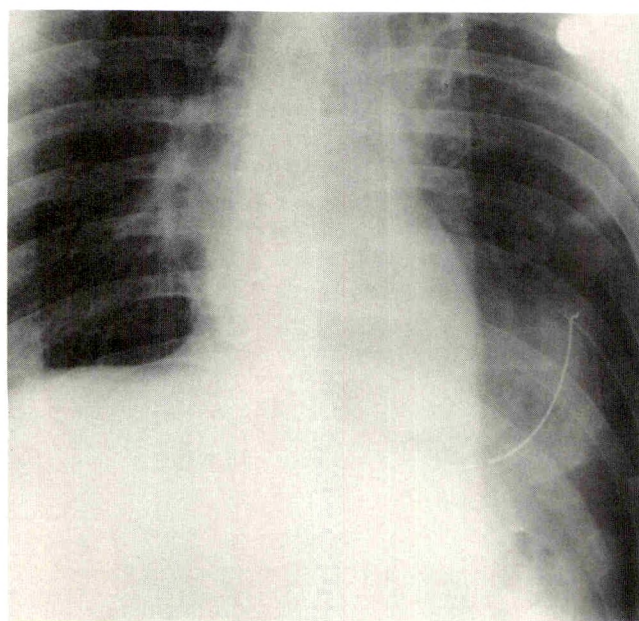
Chest radiograph reveals marked displacement of nasogastric tube into left lower hemithorax, suggesting gastric herniation. Contour of left hemidiaphragm is not clearly defined. An air lucency extends from abdomen into hemithorax. Fractures of seventh through ninth ribs were present on right side. Surgery revealed rupture of left hemidiaphragm with herniation of stomach, colon, and spleen into left hemithorax.
